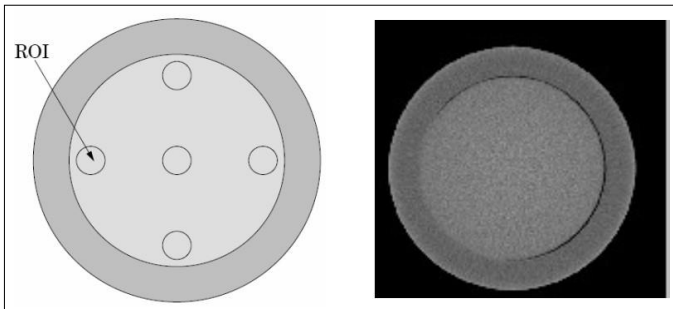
Measurement of uniformity on a CT and CBCT images using the CTP729 module.
